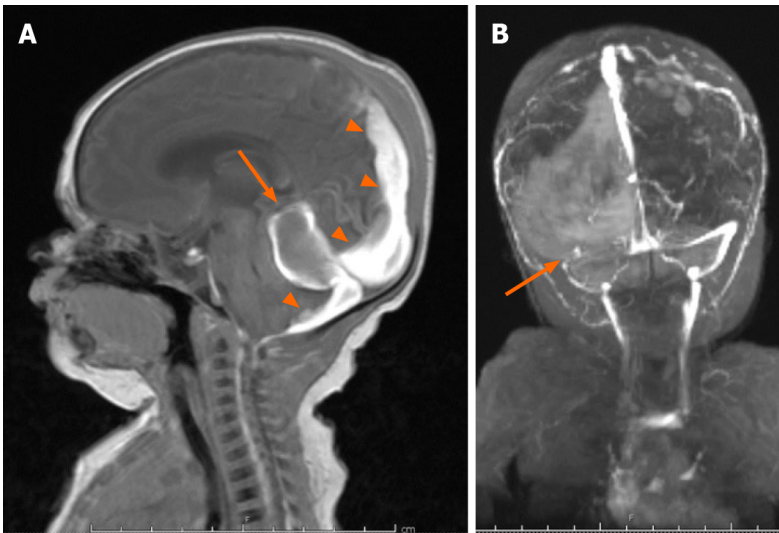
Brain magnetic resonance imaging on 10th day of life. A: Follow-up brain magnetic resonance imaging on 10th day of life re-demonstrates the posterior fossa mass (arrow), with interval high signal on sagittal T1 consistent with evolving blood products, as well as persistent subdural hematoma (arrowheads); B: PA coronal MRI venography demonstrates absent flow in the transverse sinus consistent with transverse sinus thrombosis.
